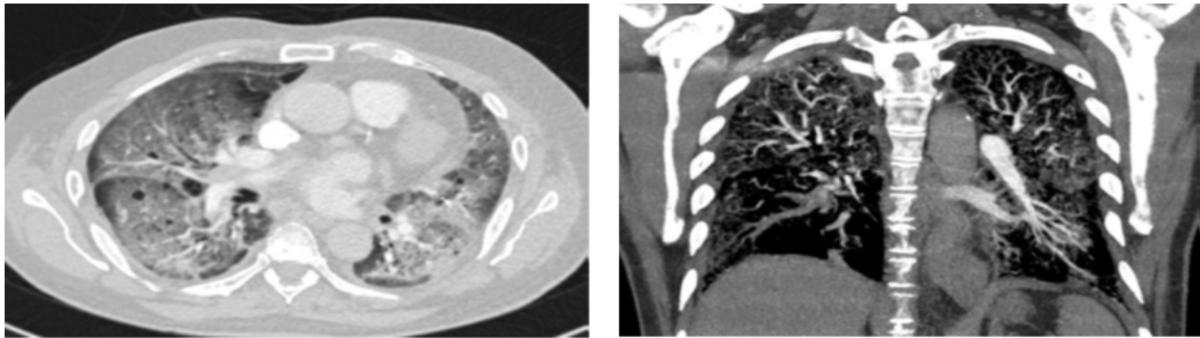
Lung window of case 4 showing features of COVID 19 infection CT severity score of oblique sagittal MPR CT pulmonary angiography shows partial and complete filling defects in left lower segmental and subsegmental branches
